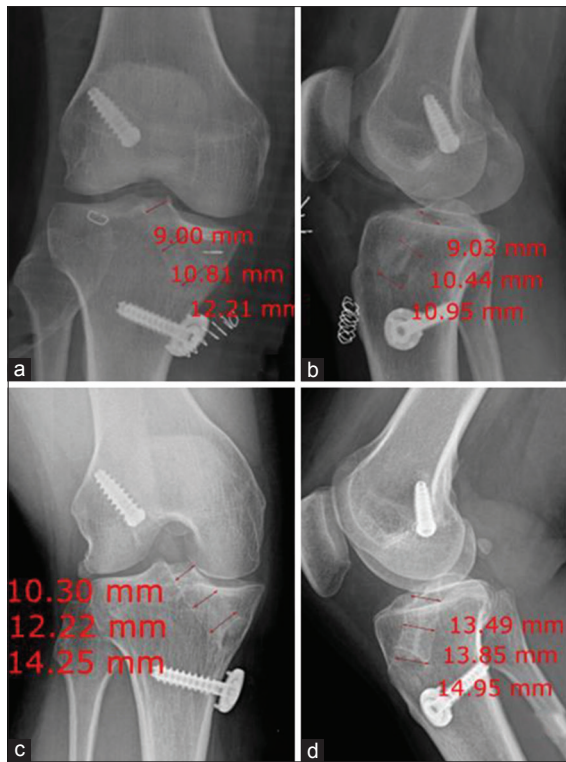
The case with the greatest extent of tibial tunnel widening. A 44-year-old female patient underwent anterior cruciate ligament reconstruction and was followed up for 21 months. (a and b) X-ray knee joint anteroposterior and lateral views on postoperative day 1 showing the diameters of the tibial tunnel were measured as 9.0, 10.8, 12.2, 9.0, 10.4, and 11.0 mm (distal, middle, and proximal, respectively). (c and d) X-ray knee joint anteroposterior and lateral views after 21 months, showing radiographs revealed that the tibial tunnel had widened as the tunnel's diameters increased to 10.3, 12.2, 14.3, 13.5, 13.9, and 15.0 mm. The mean diameter was 10.4 mm on postoperative day 1 and 13.2 mm at followup, which is a change of 2.8 mm
